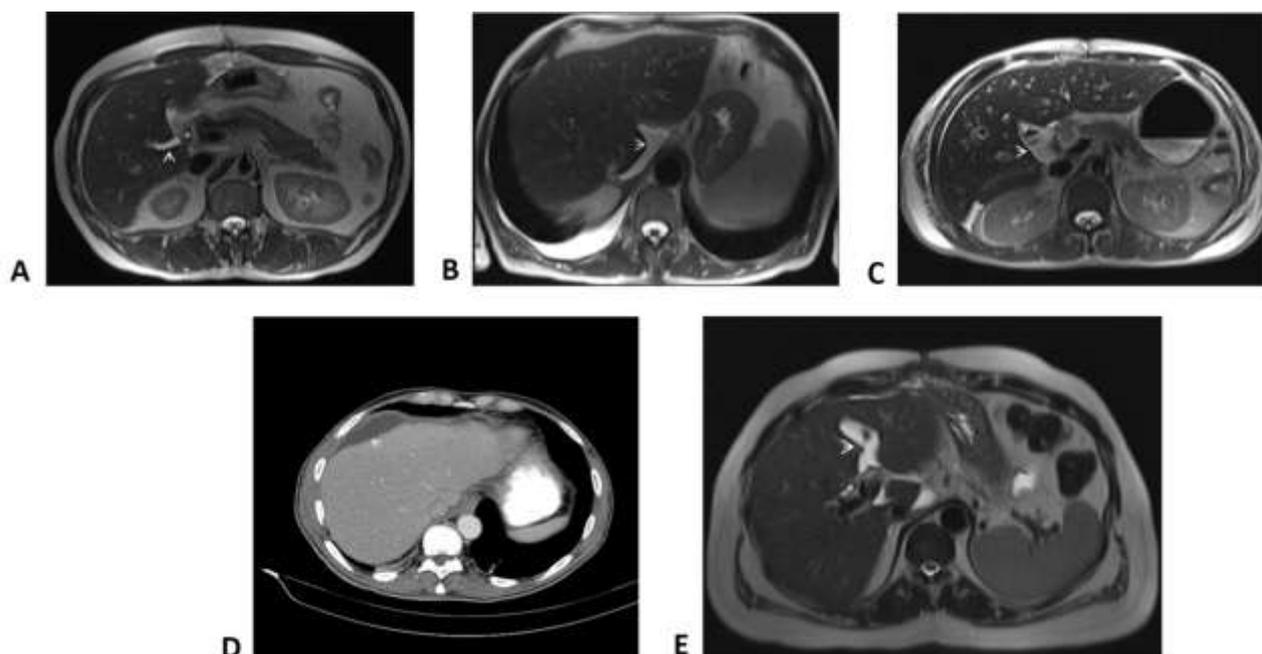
Common locations of post-transplant fluid collections (A-E) demonstrating simple fluid collections. A. Axial T2 WI -Cleft between segment 5/6(*arrowheads*): most common. B. Axial T2 WI -Pericaval region/ ligamentum venosum (*arrowhead*); second most common site. C. Axial T2 WI - Porta Hepatis (*arrowhead*); third most common site. D. Axial iv contrast enhanced CT-Pericapsular/subdiaphragmatic (*arrowhead*); fourth most common site. E. Axial T2 WI -Fissure for ligamentum teres, (*arrowhead*); fifth most common site.
